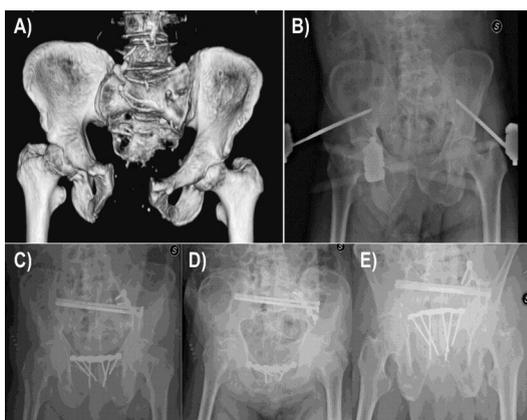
A) 3D CT reconstruction: pelvic ring B1 injury according to Tile and APC 2 injury according to Young Burgess. It is possible to appreciate sacral dysmorphism (Bertolotti's Syndrome) with hemisacralization of L5 on the left side; B) anteroposterior X-ray after damage control with supracetabular external fixator; C-E) post-operative X-ray: AP, inlet and outlet view after reduction and fixation with anterior 3.5 sacroiliac plate and two 7.3 trans-sacral screws; the pubic symphysis was fixed with a 3.5 dedicated plate and six screws (LiuZZA F, 2019)
